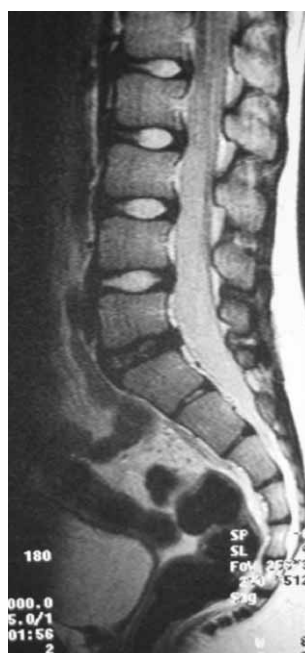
MR, T2-weighted sequence in sagittal cut: DD of L5-S1 segment, stage IV. Patient S.T., 16 years (boy.)
